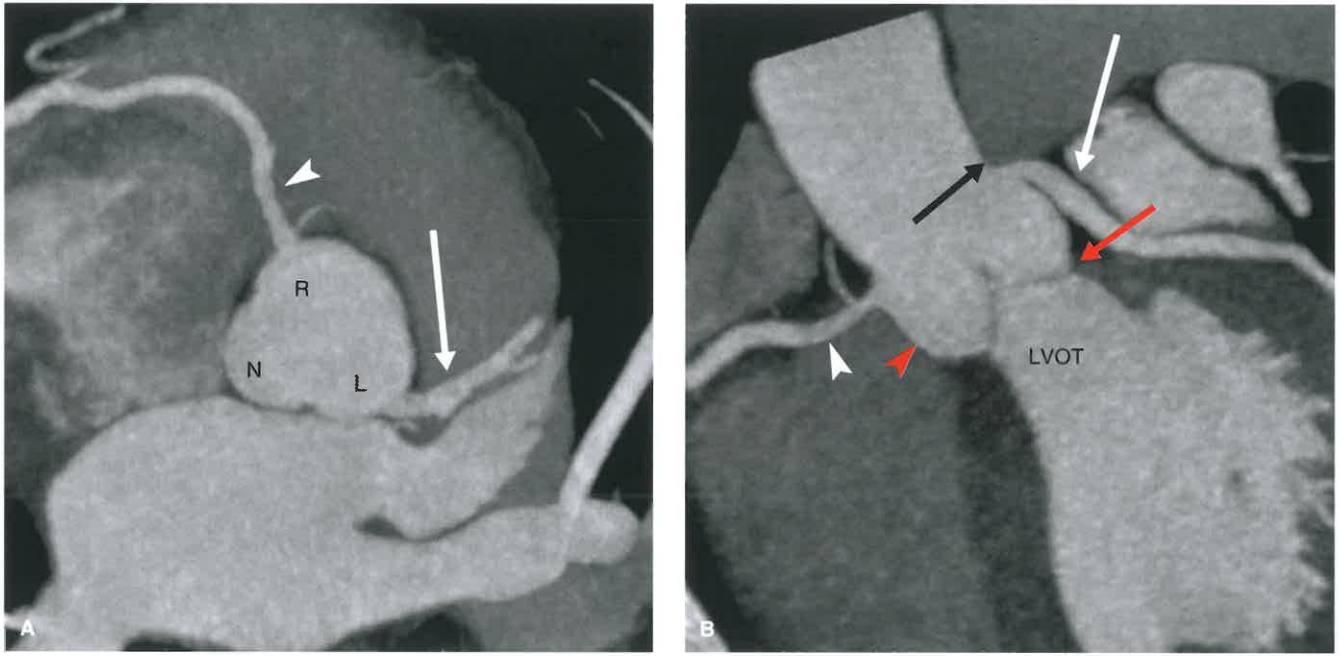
Normal Coronary Ostial Anatomy. A: A 7-mm thick MIP image transverse to the aortic sinus from a coronary CTA shows the left (L), right (R), and noncoronary (N) sinuses. The left main coronary artery (*white arrow*) and right coronary artery (*white arrowhead*) arise normally from the left and right coronary sinuses, respectively. B: Coronal oblique 5-mm thick MIP image through the left ventricular outflow tract (LVOT) shows that the ostia for the left main (*white arrow*) and right (*white arrowhead*) coronary arteries originate from the aortic root between the level of the sinuses of Valsalva (*red arrowhead*) and sinotubular junction (*black arrow*). The aortic valve leaflets attach at the annulus (*red arrow*) which separates the LVOT from the aortic root.
